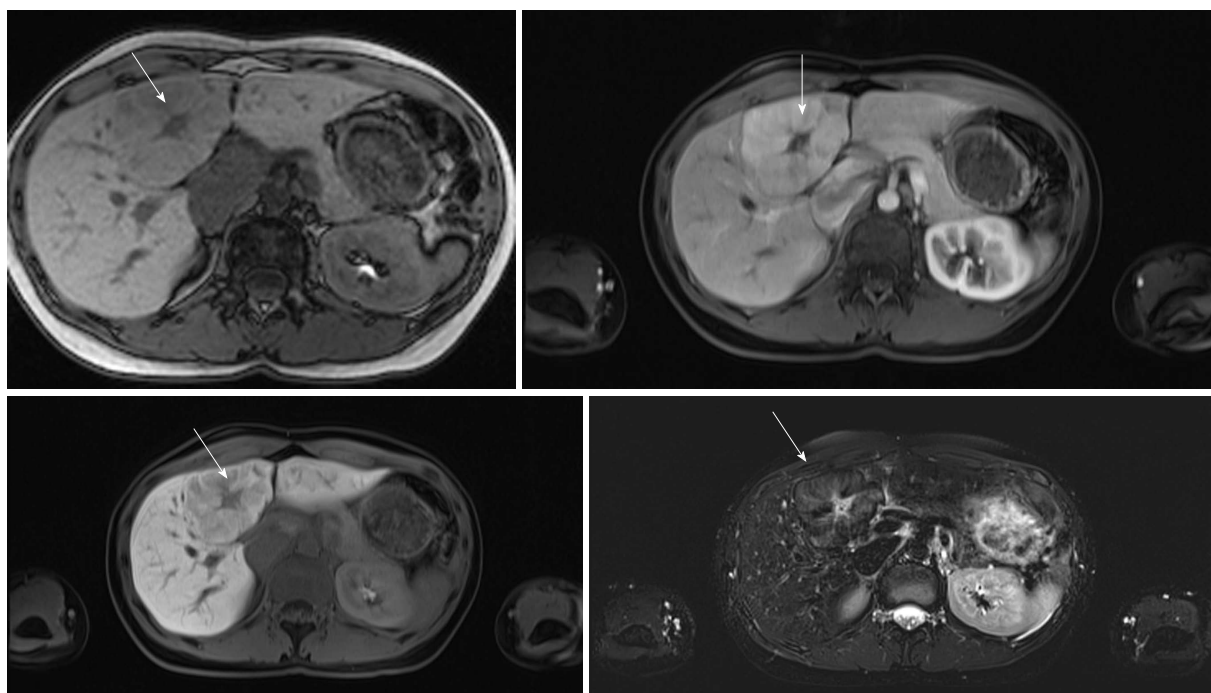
Contrast enhanced magnetic resonance images of focal nodular hyperplasia. A 30 years old female, medically free, had abdominal pain; ultrasonography showed gallstones and liver lesion (arrows shows the lesion with the characteristic central scar of FNH).
